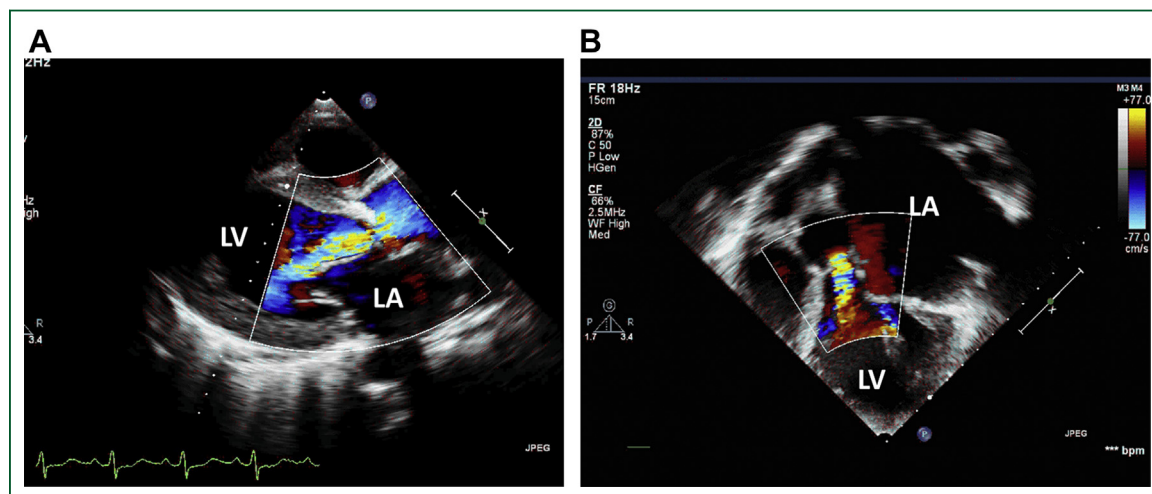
Parasternal long-axis (A) and apical 3-chamber (B) views showing color jet of aortic regurgitation. Abbreviations as in Figure 1.
